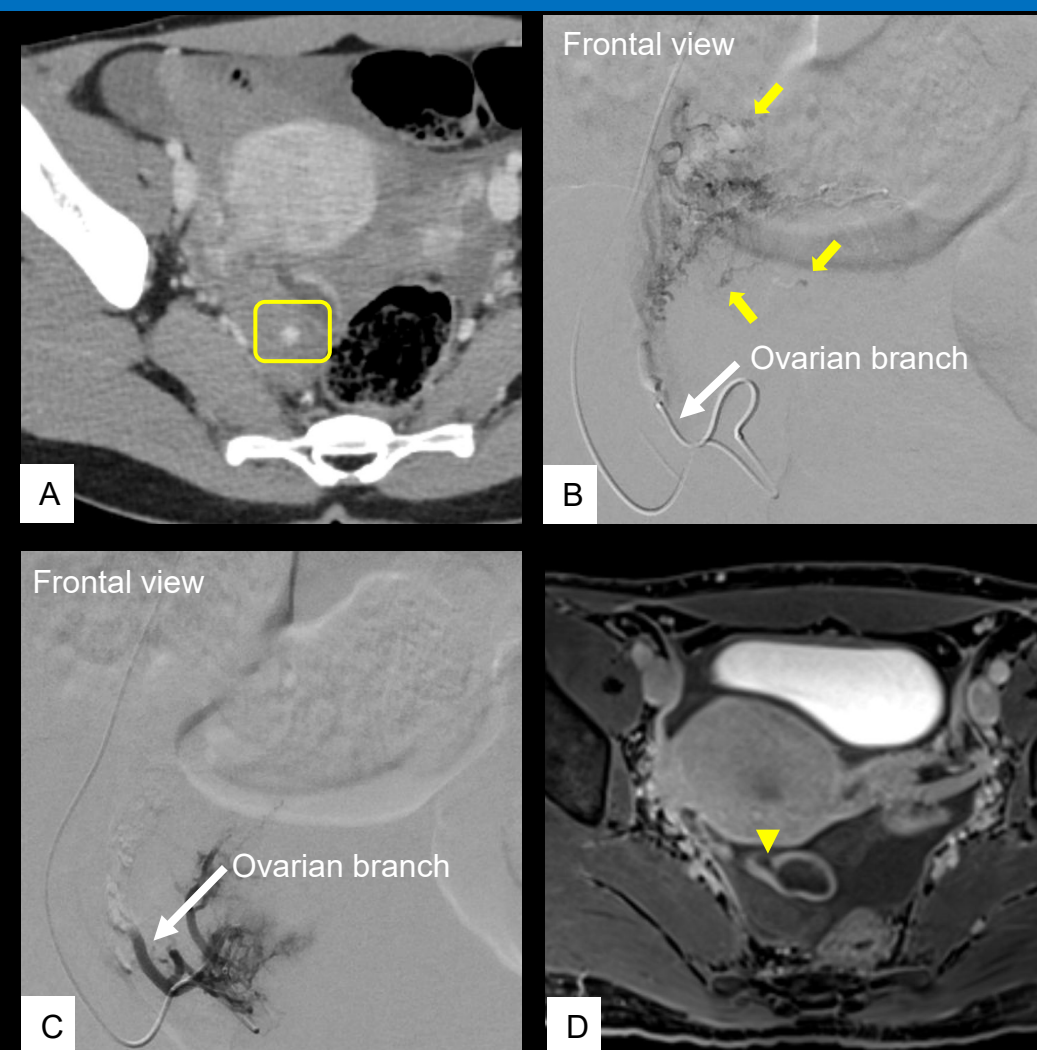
(A) Enhanced axial CT image shows extravasation (yellow square). (B) Angiogram of the ovarian branch of the right uterine artery shows extravasation (yellow arrows). (C) Angiogram after embolization shows disappearance of extravasation. (D) Enhanced magnetic resonance imaging 2 days after the procedure reveals findings suggestive of a ruptured corpus luteum cyst (yellow arrowhead).
